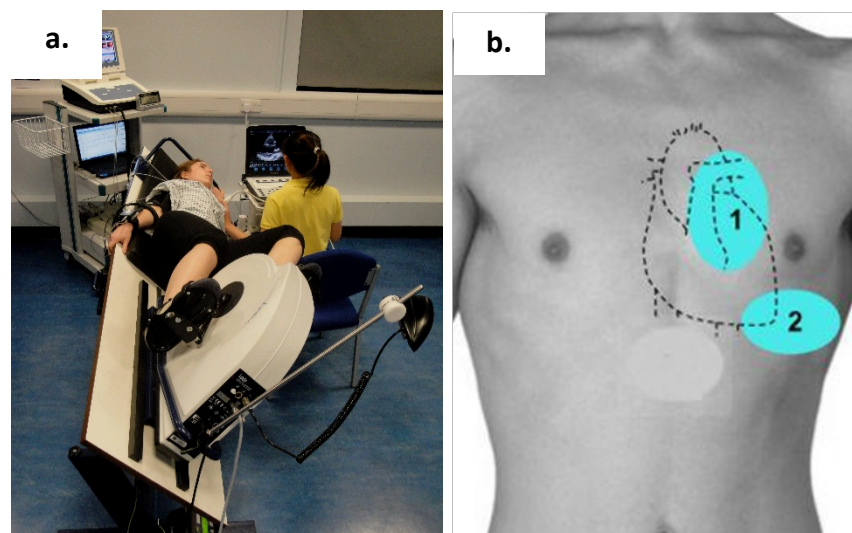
a. Collection of a resting echocardiography scan. b. Echocardiographic probe positions.
